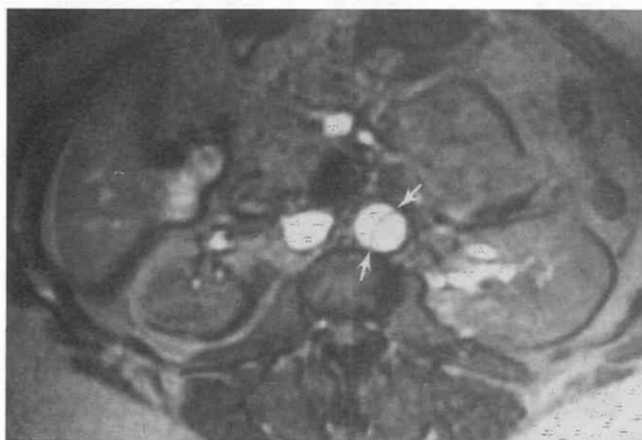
Aortic dissection. Limited flip-angle MR image demonstrates the intimal flap (arrows) between the bright signal in the true and false lumina.
